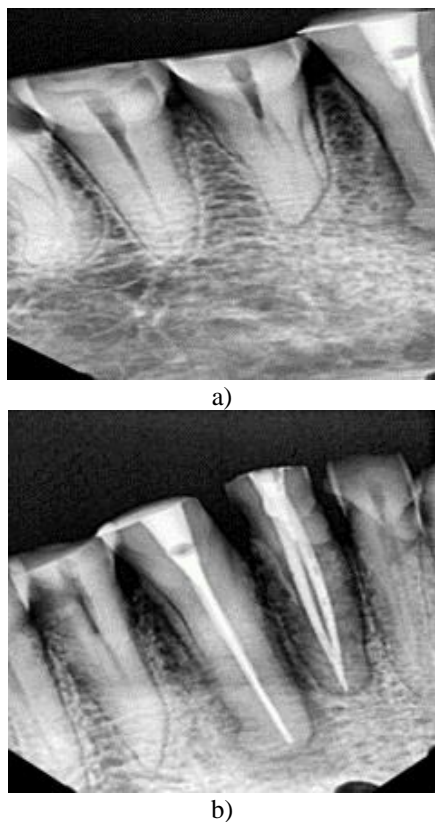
a) Preoperative radiograph reveals presence of two canals. b) Post obturation radiograph shows well obtured two canals with vertucci type II configuration.
